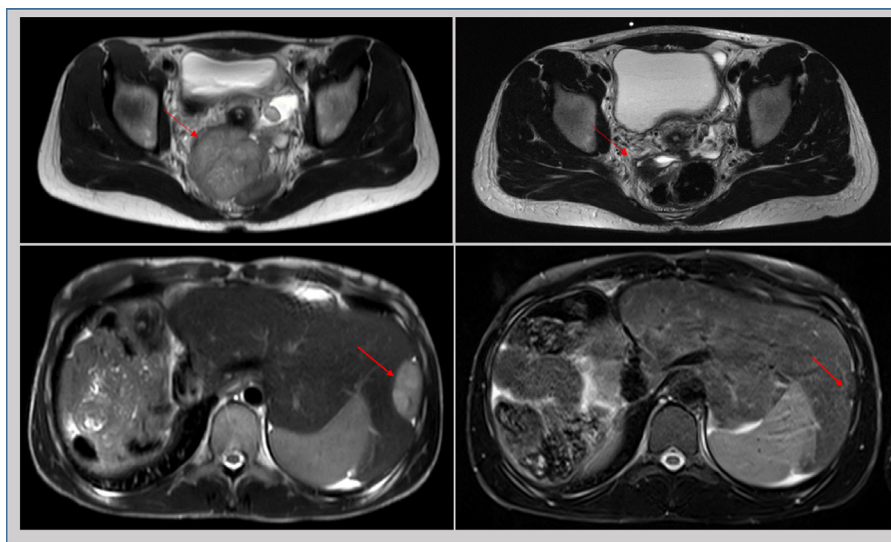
Representative figures of MRI scans at baseline (left panels) and after four cycles of immunotherapy (right panels) exemplarily showing the regression of the pelvic and a peritoneal lesions indicated by the arrows.
